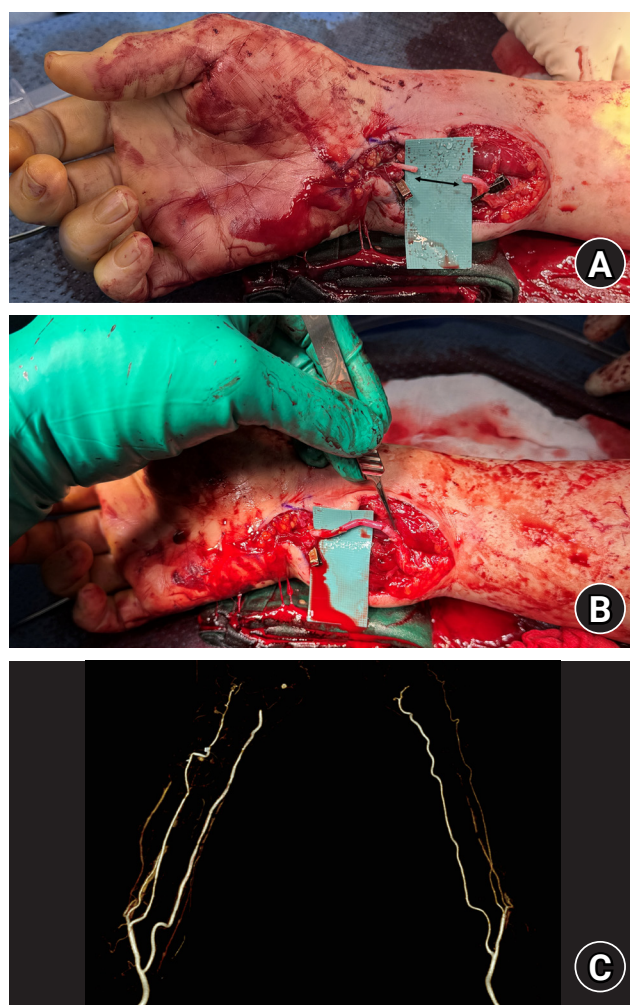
Intraoperative photographs showing ulnar artery reconstruction for a segmental defect. (A) After debridement, an approximately 2-cm segmental defect remained in the ulnar artery. (B) The defect was reconstructed with a reversed interposition vein graft harvested from the ipsilateral basilic vein. (C) Postoperative three-dimensional computed tomography angiography confirming patency of the reconstructed ulnar artery.
